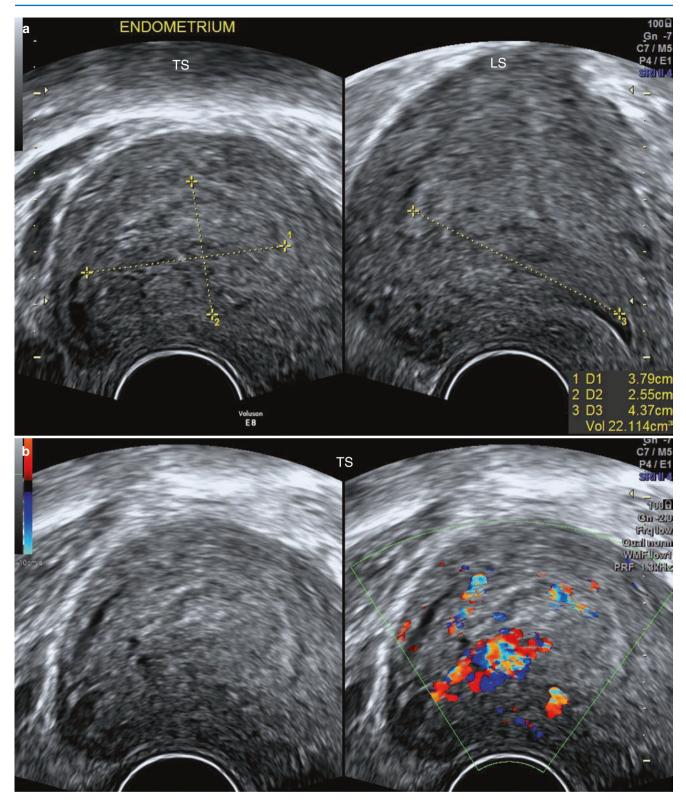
RPOC following TOP at 17+ weeks of pregnancy. (a) Retained tissue which appears isoechoic with the surrounding myometrium is seen in the endometrial cavity - measured in this image. (b) Its presence was ascertained with the help of Doppler, which showed high vascularity within the mass
